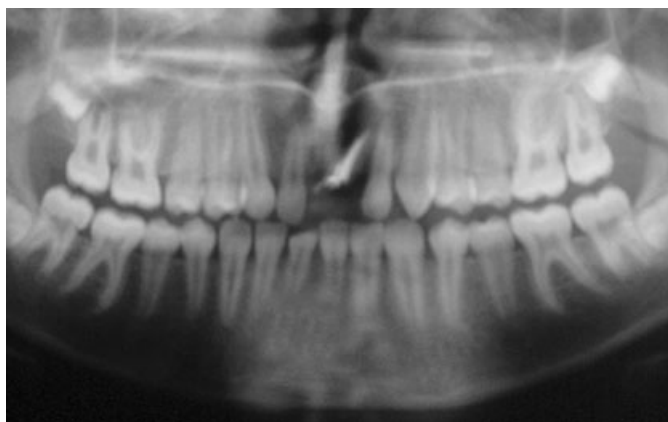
The radiographic view of the patient before treatment.
